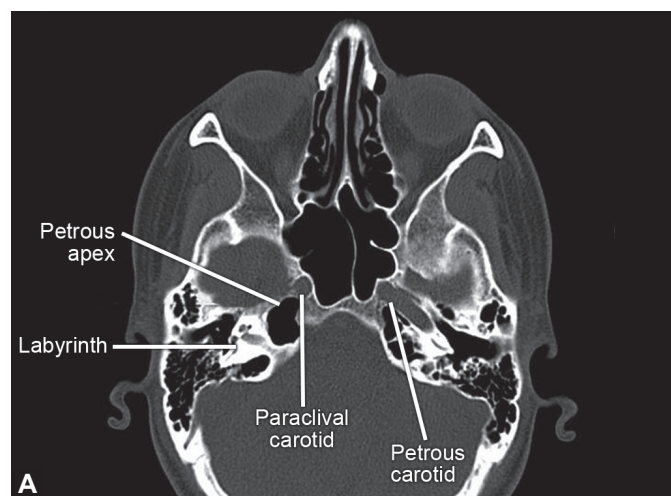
Nonpneumatized petrous apex anatomy. Axial computed tomography (CT). (PPT: Pterygopalatine fossa).
